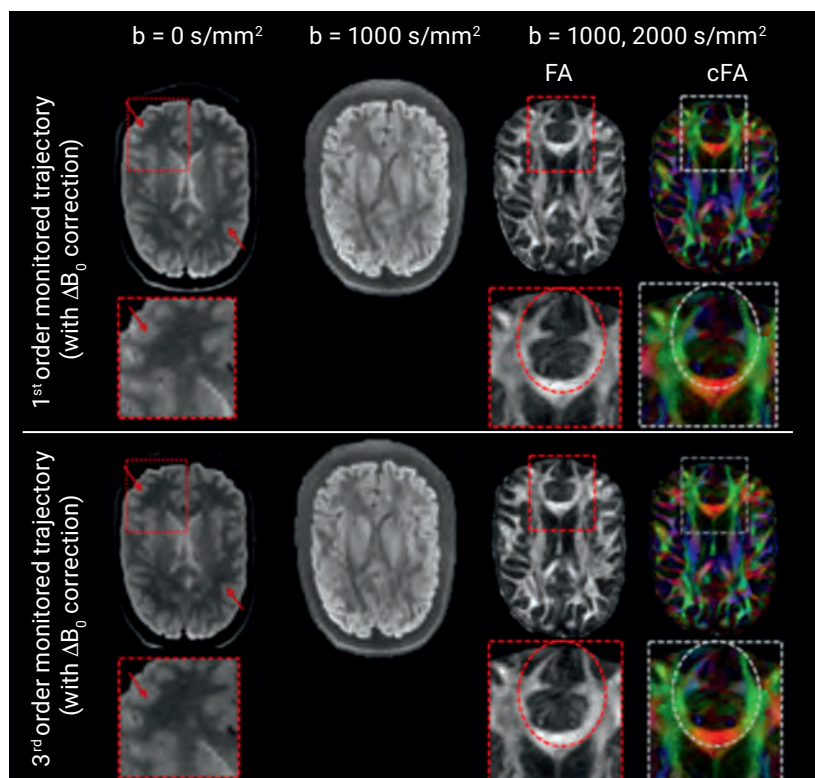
Reconstructed images with 0.8 mm isotropic resolution for $b = 0$ s/mm², single direction diffusion weighted data ($b = 1000$ s/mm²) and directionally-encoded fractional anisotropy (FA) and coloured FA (cFA) with multi-shell ($b = 1000, 2000$ s/mm²) DWI data for monitored first- and third-order readout trajectories with ΔB_0 off-resonance correction. For third-order monitored trajectories, blurring is reduced (arrows) and finer anatomical details are visible (e.g. in the frontal lobes; dashed circles), compared to only first-order. Diffusion weighted data were acquired with 60 diffusion directions per shell (with 20 interleaved $b = 0$ s/mm²).
